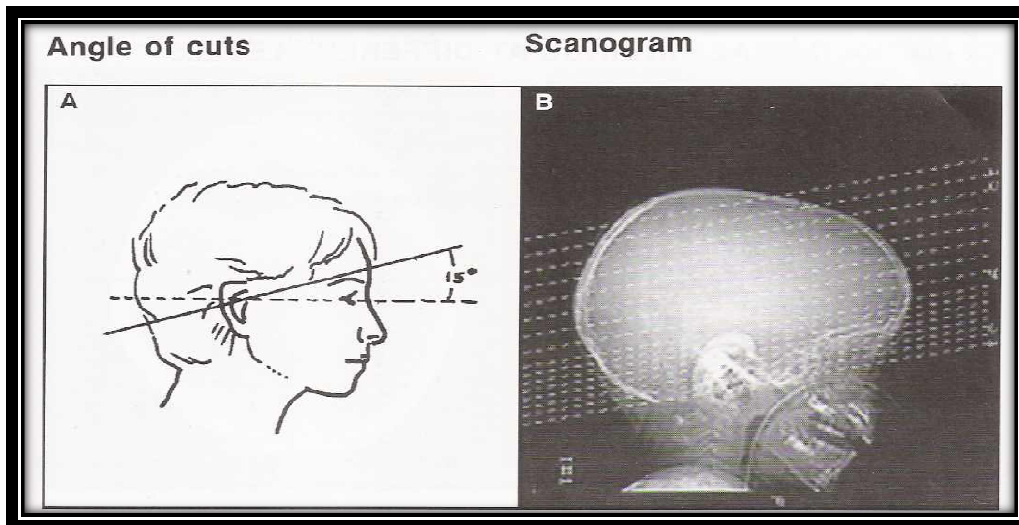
shows scanogram (scout view) and angle of cuts in children head CT
